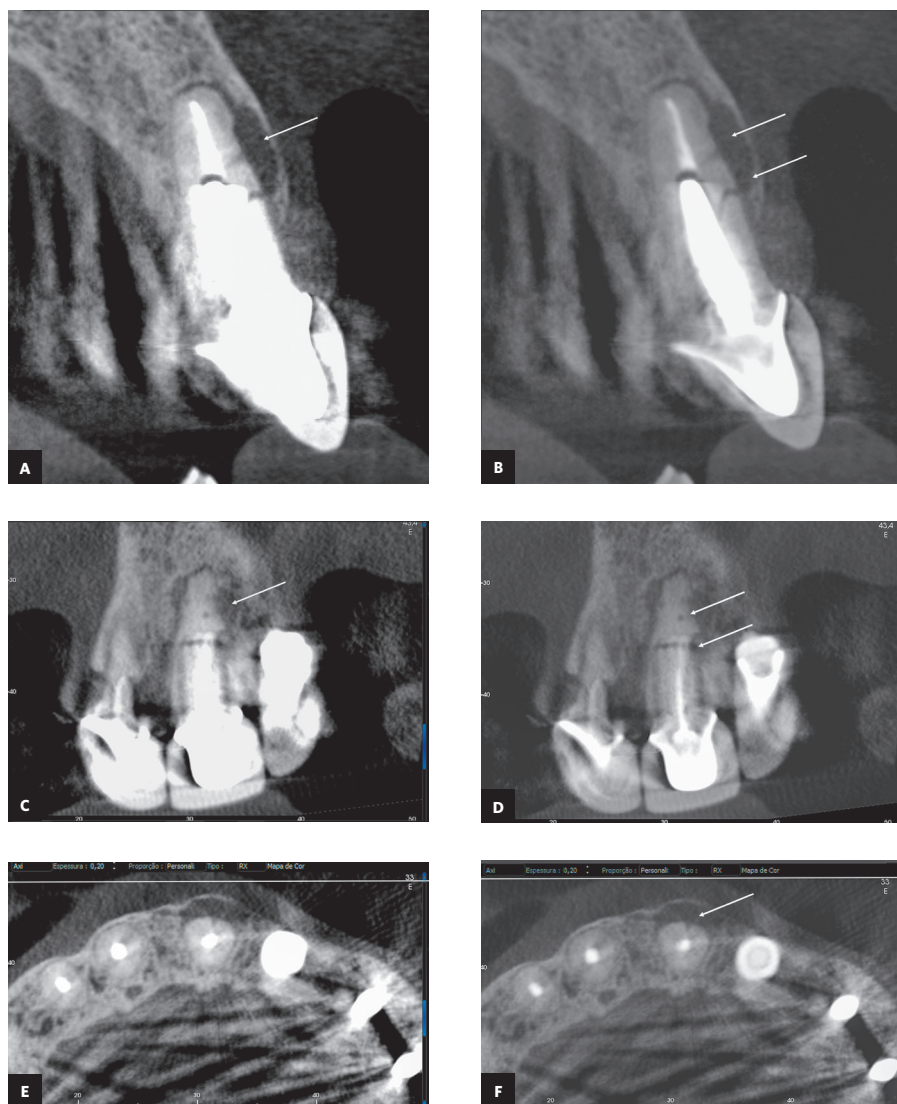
The original CBCT scans (A, C, E) shows white contrast artifact in tooth #21 with a large dimensional volume of intracanal post occupying the middle and coronal thirds and complete absence of dental structure; (B, D, F) The BAR filter was applied to reduce white contrast artifact making it possible to clearly see a fracture line associated with the intraradicular post. Additional navigation on CBCT scans revealed a low-density line suggestive of a lateral canal associated with the buccal low-density lesion superior to the fracture line.
